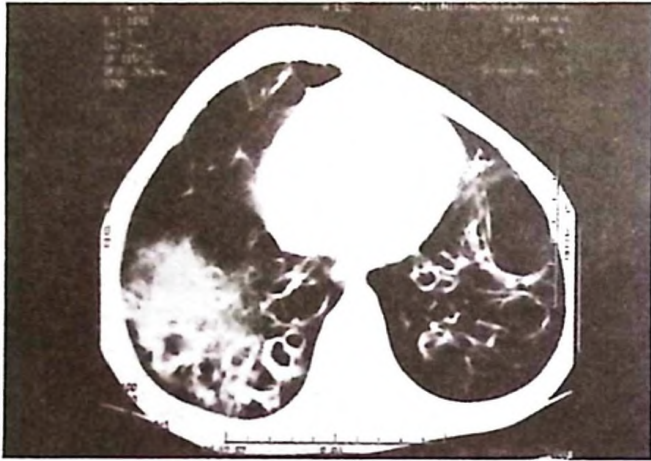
Thoracic computed tomography (CT) scan in 1995 demonstrated newly developing cystic bronchiectasis affecting both the lower lobes and the middle lobe. The bronchiectasis was more severe in the left paracardiac region (arrow).
